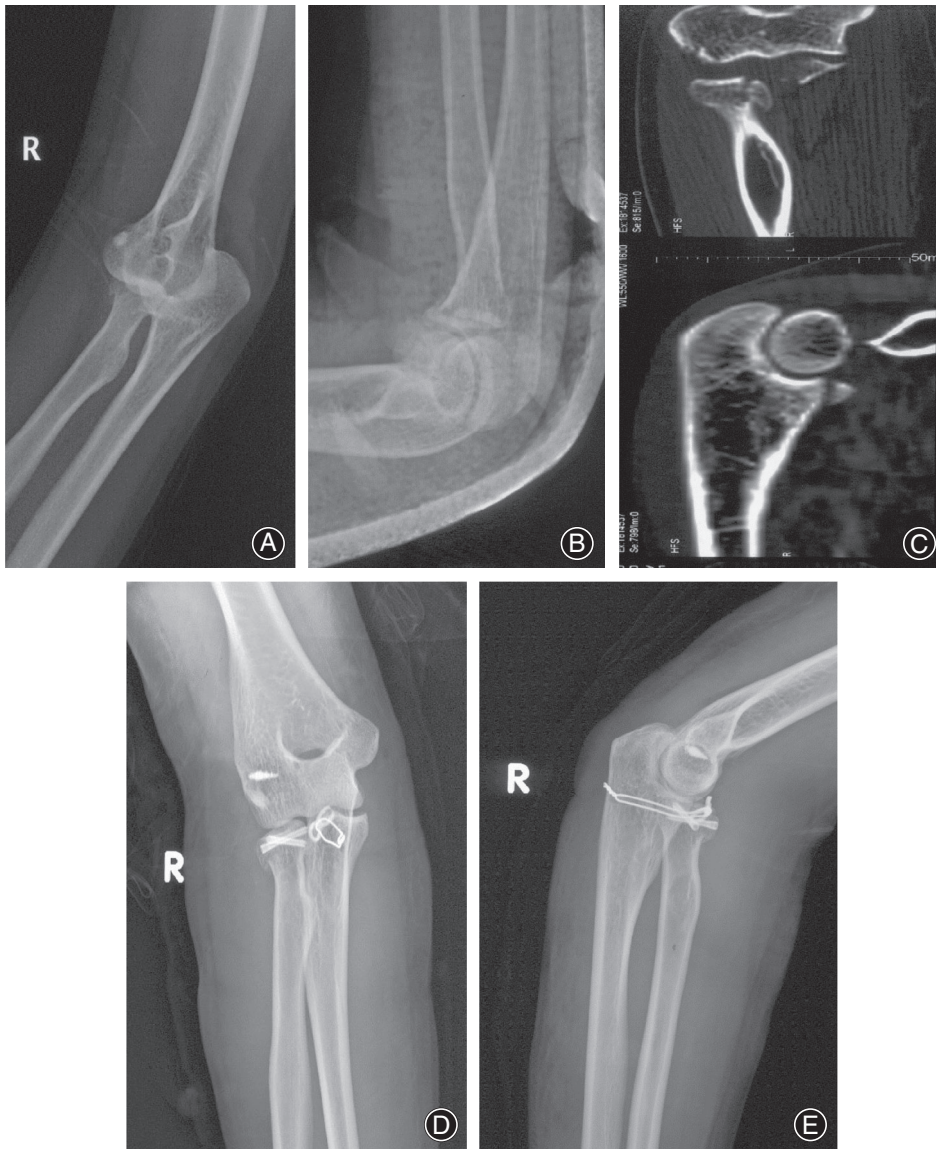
The terrible triad of the right elbow, the ulnar coronal process was fixed with loop steel plate, the radial head was fixed with countersunk head nail, and the lateral ligament complex was repaired with thread rivet. Preoperative X-ray examination of elbow joint (A, B) CT examination of (C). X-ray examination of elbow joint on the second day after operation (D, E).
